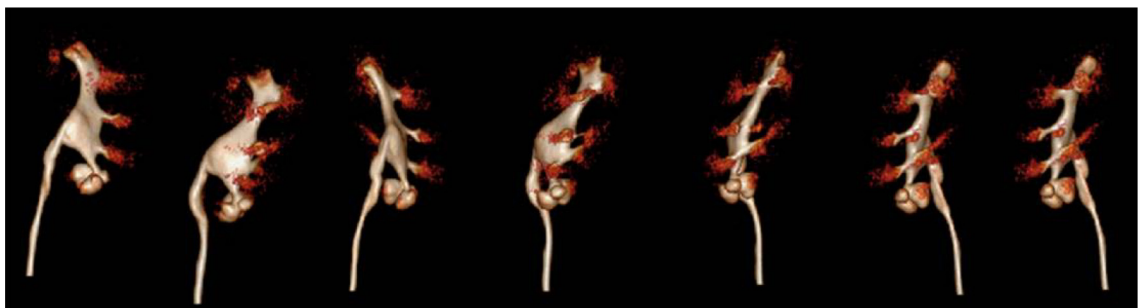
Pelvicaliceal and ureteral excretory phase demonstrating the infundibulum-pelvic angle (IPA) measurement in the same renal unit. Image obtained with three-dimensional helical computed tomography.
